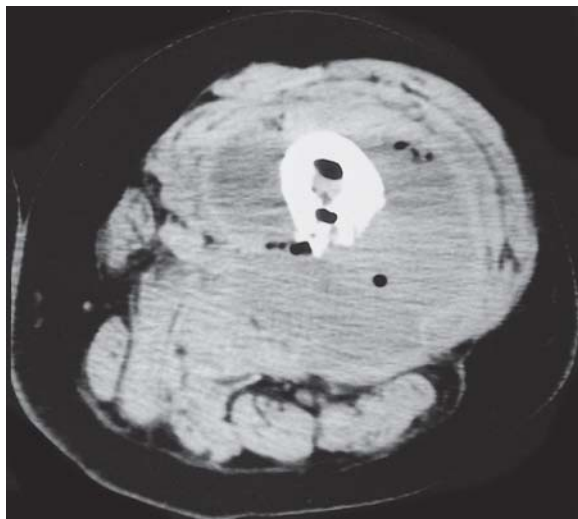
Gas-forming clostridial osteomyelitis of the femur in a 59-year-old man. Computed tomography. Loculi of gas are present within the bone and surrounding abscess
